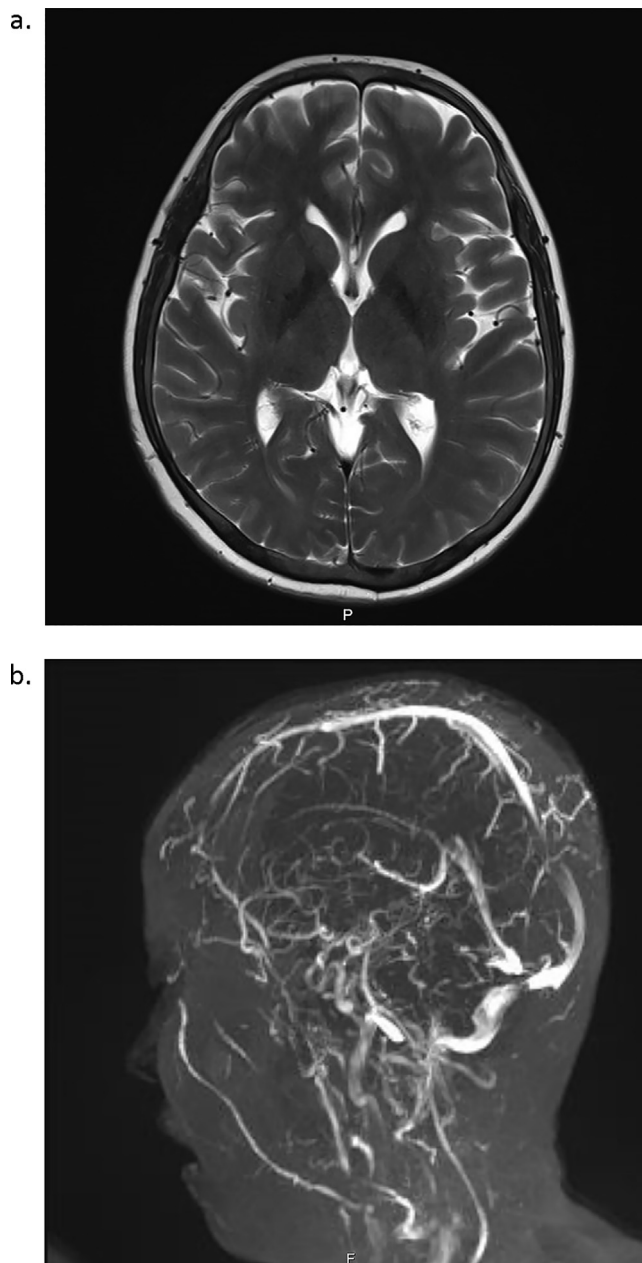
(a) Cranial MRI. (b) MR venography.
